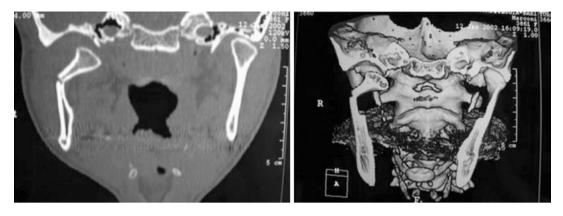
CT scan in a coronal reconstruction (left) and 3D reconstruction (right), showing a condylar fracture with a medial displacement
